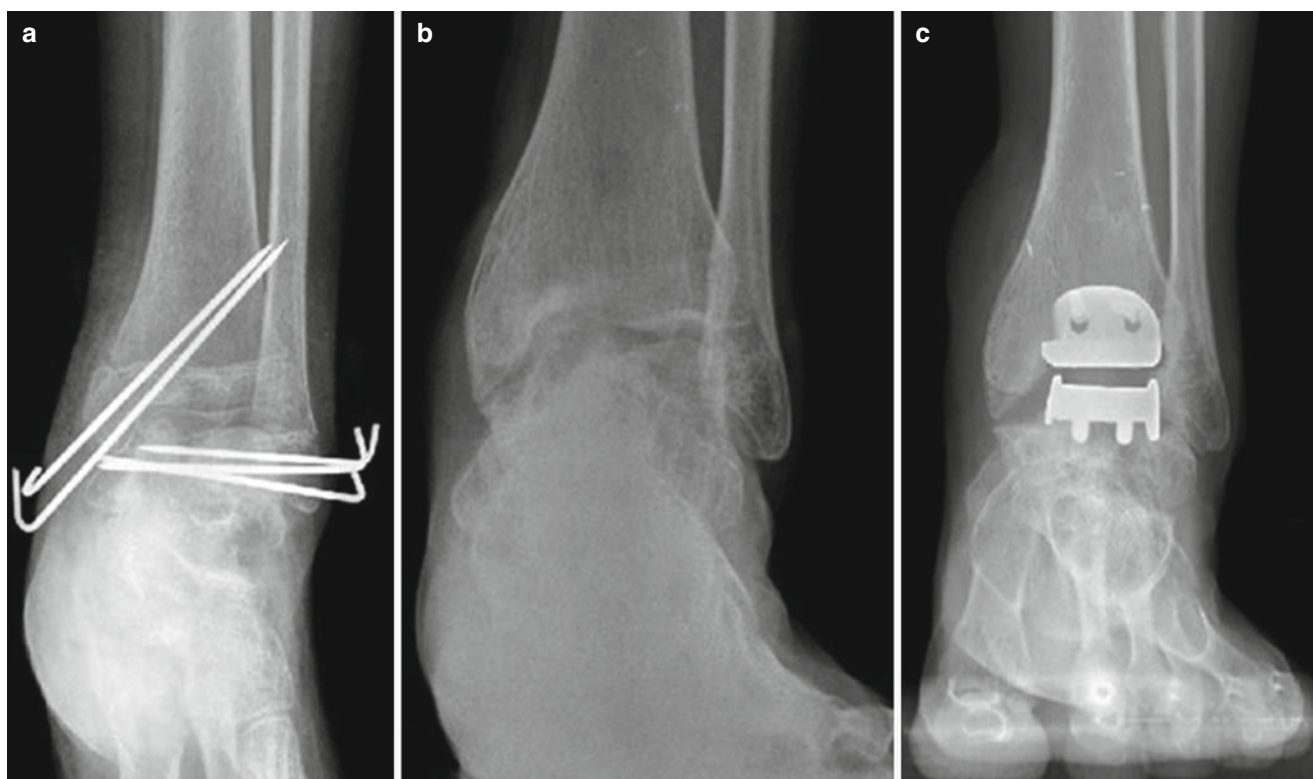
(a) Left ankle anteroposterior radiograph of 13-year-old boy who had a talar fracture and a medial malleolar fracture on his left ankle. He underwent open reduction and internal fixation. (b) Six years later, his left ankle had a collapse of the talus and joint space narrowing
